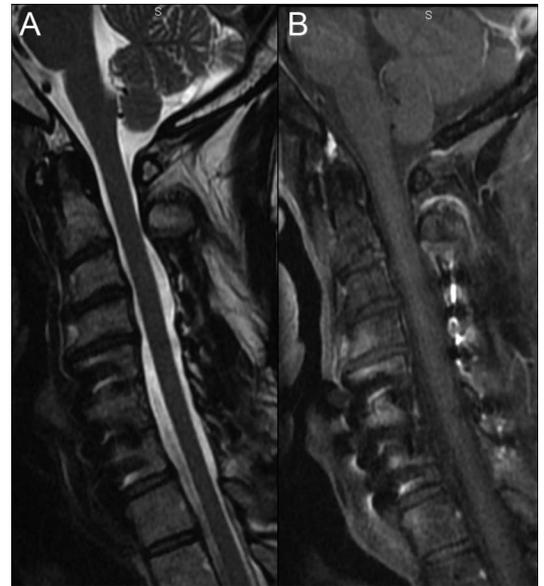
Pretreatment MRI
